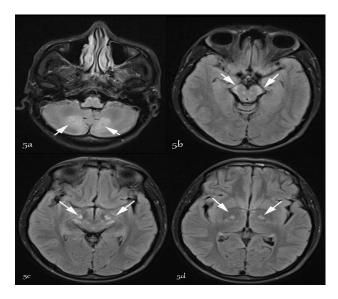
(A-D): Follow up MRI of brain in brother showing symmetrical signal hyperintensity involving cerebellum hemisphere (a), cerebral peduncle of mid brain (b. c), basal ganglia, posterior limb of internal capsule in (d) flair images.
